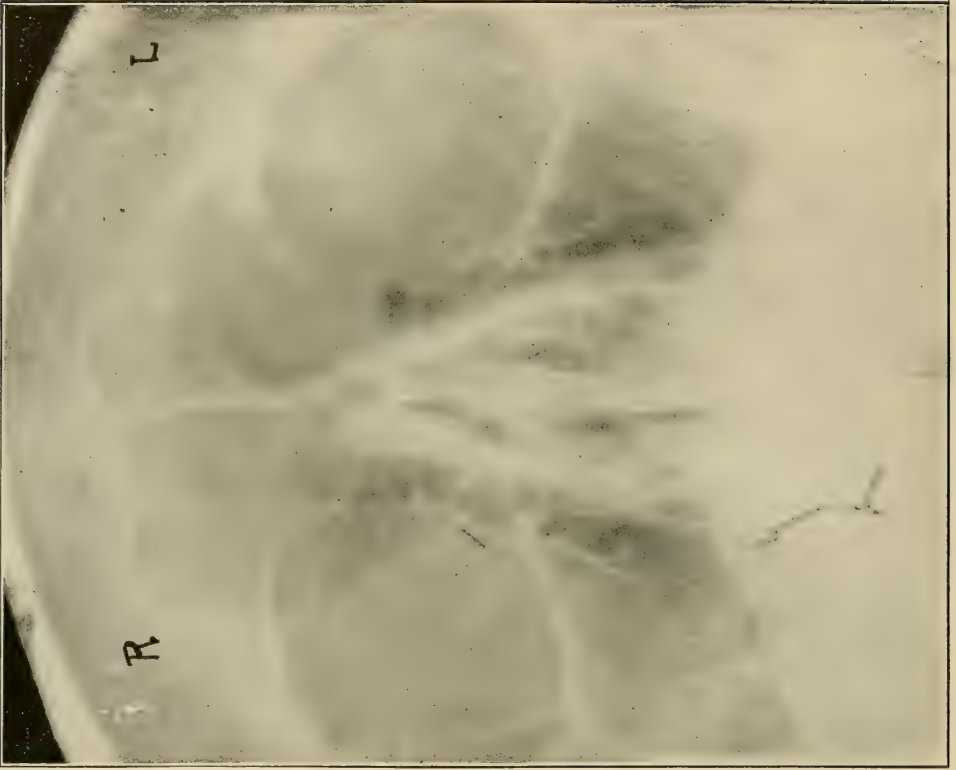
Radiograph made from pose, Fig. 372. (*Interstate Medical Journal.*)
